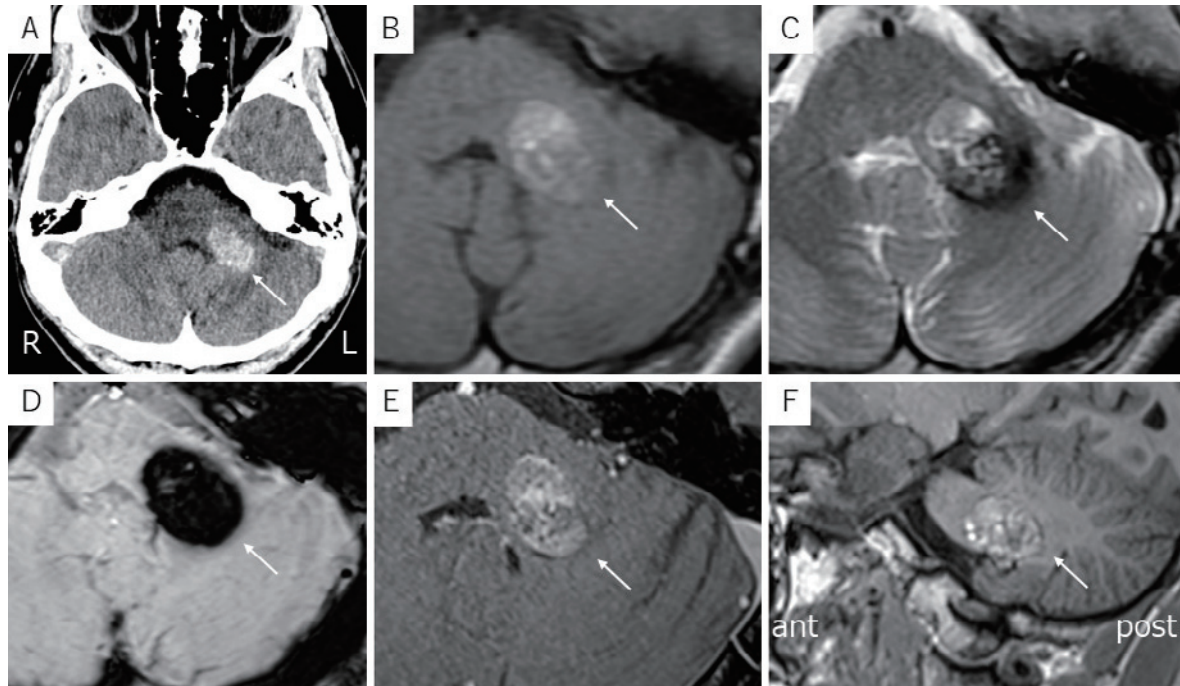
A: Computed tomography (CT) on admission showing a high-density mass lesion in the inferior cerebellar peduncle (arrow).
